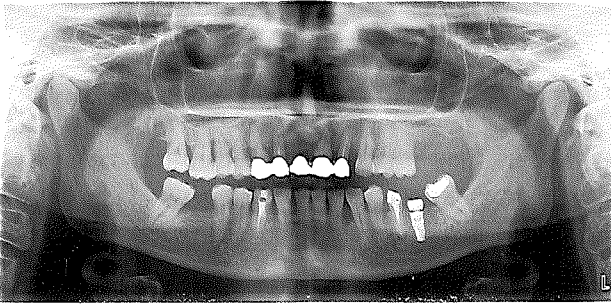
Pre-surgical radiograph.
